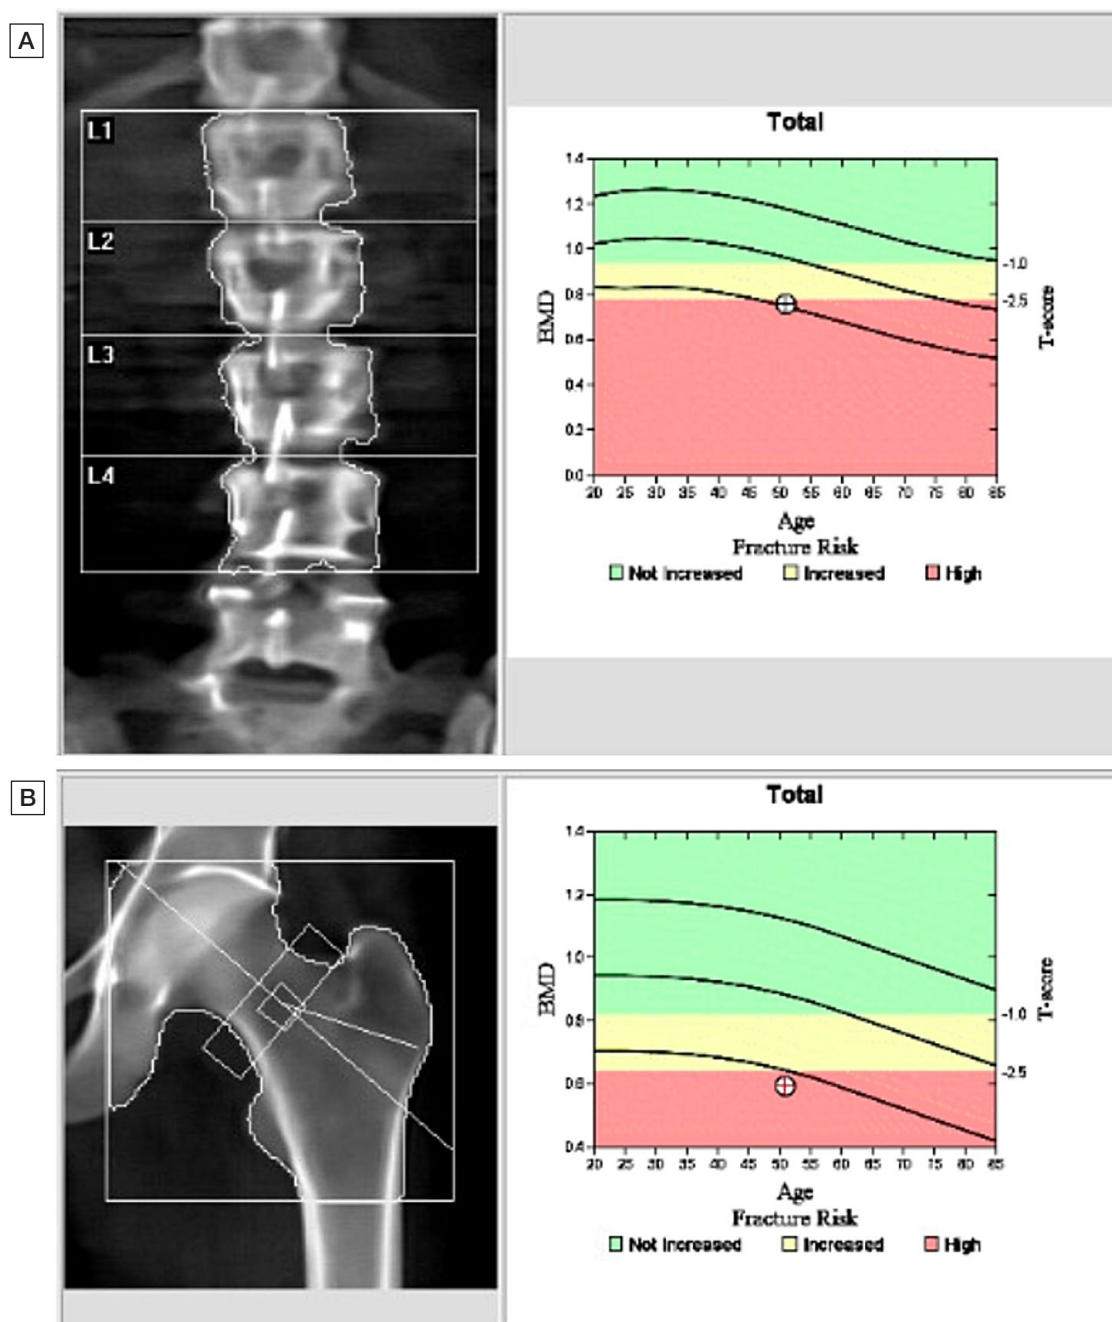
Dual-energy X-ray absorptiometry of the lumbar spine, L1-L4 [A] and left femoral neck [B] showing a T-score of ≤ -2.5 , compatible with osteoporosis, with increased fracture risk.
